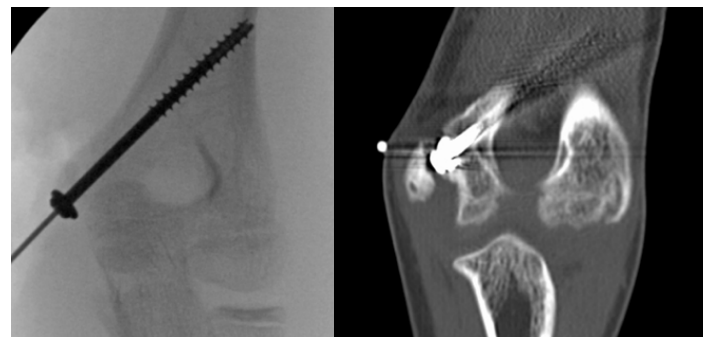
(left). Intraoperative x-rays. Figure 12 (right). Three months postoperative CT showing hardware cutout and nonunion.
